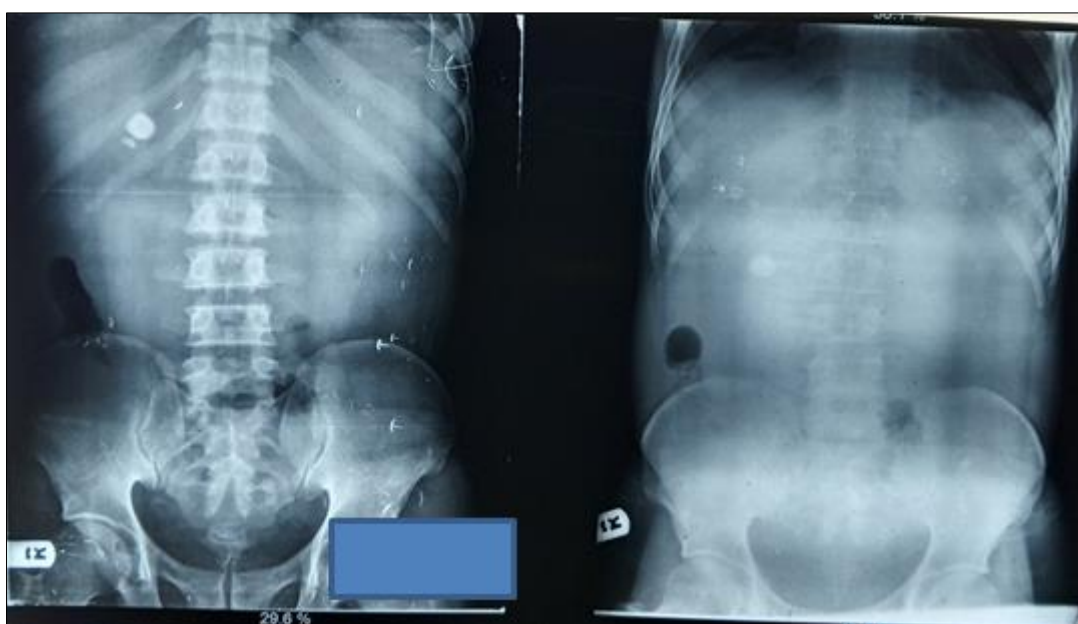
Plain radiographs of the abdomen demonstrating lucency along the gallbladder region; pneumobilia, two-oval opacities of calcific density above and lateral to the shadow of the upper lobe of the right kidney; gallstones (image on the left), these are noted to descend inferiorly changing location on the right image, ground-glass opacity with paucity of bowel loops raising a suspicion of bowel perforation. These features are components of the Rigler's triad of gallstone ileus
